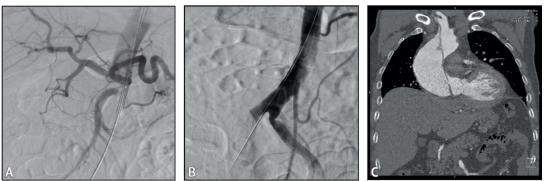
A, B - occlusion of the right common iliac artery on the right; C-CT angiography of aortic dissection involving brachiocephalic arteries
